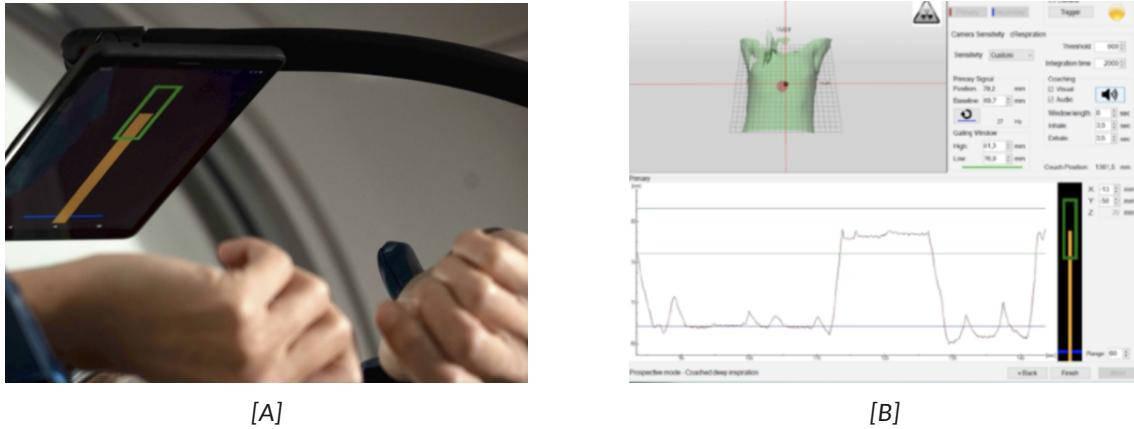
The view of [A] the patient and [B] the radiation technologist during the planning CT scan [31].
